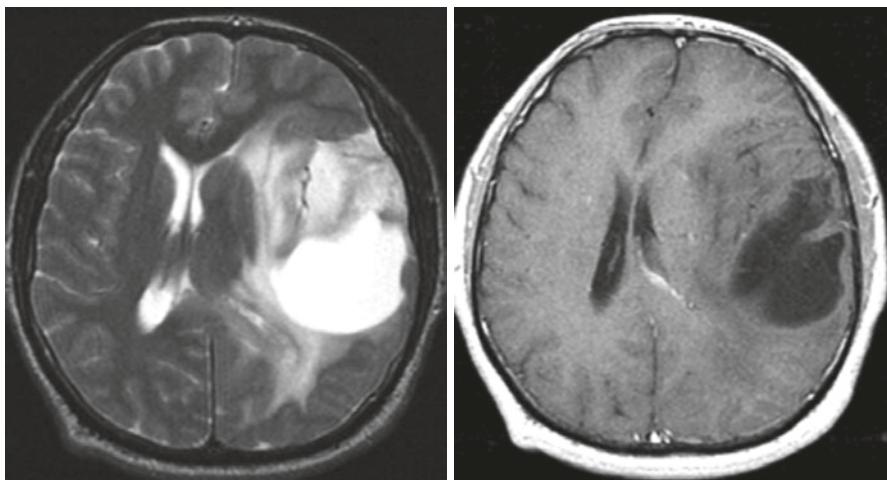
MRI axial T2 and axial T1 post gadolinium in a 35-year-old with seizures, intermittent headaches, and speech difficulties representing a glioma. (Images courtesy of Dr. Anton Hasso)
